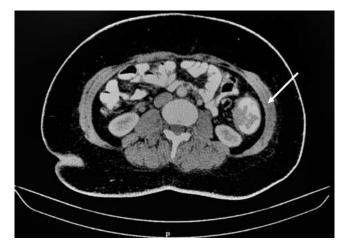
Abdomen CT scan using contrast, performed during admission, showing a sigmoid colon-dependent tumor with a large involvement of intestinal lumen.
